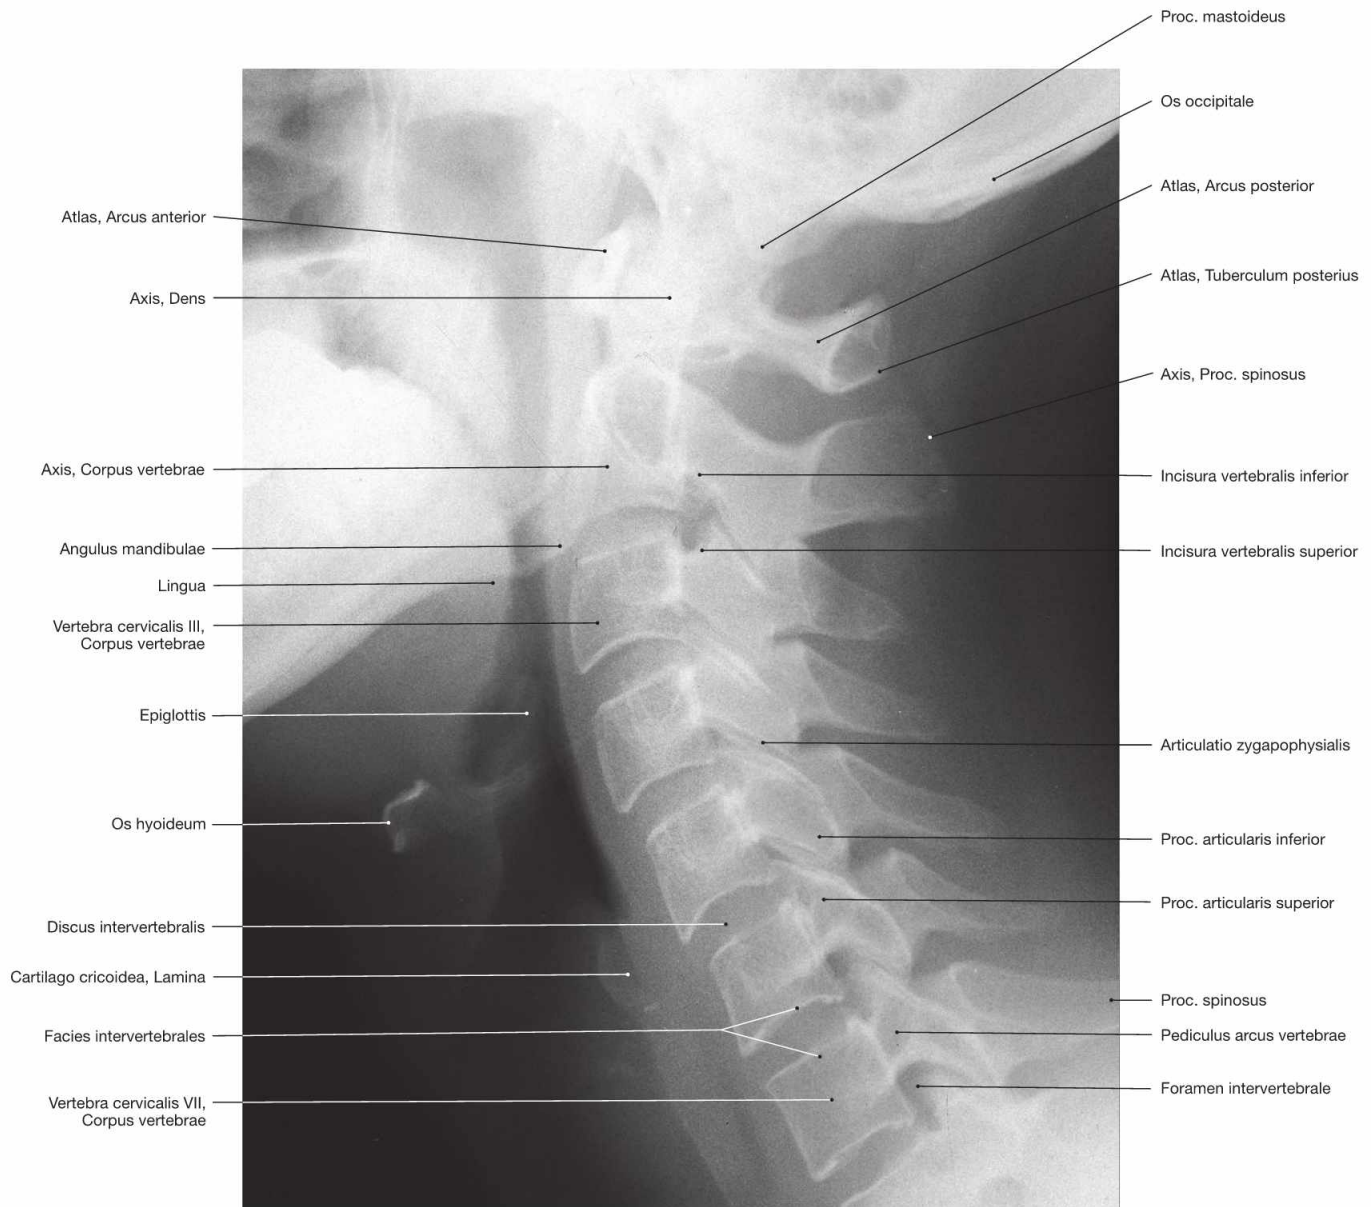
Cervical vertebrae, Vertebrae cervicales; lateral radiograph of the cervical part of the vertebral column; upright position; the central beam is directed onto the 3rd cervical vertebra; shoulders are pulled downwards.
